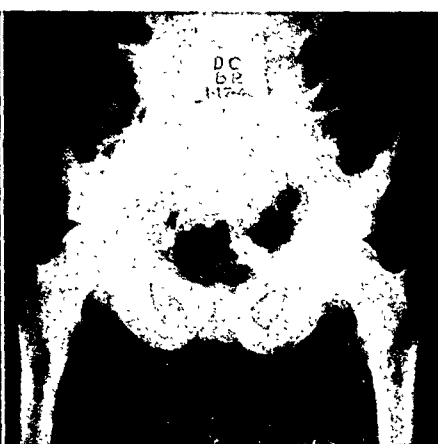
Case III. B. R. Bridge of calcification across symphysis pubis; stage of healing after course of deep roentgen therapy; disappearance of all symptoms and signs.
